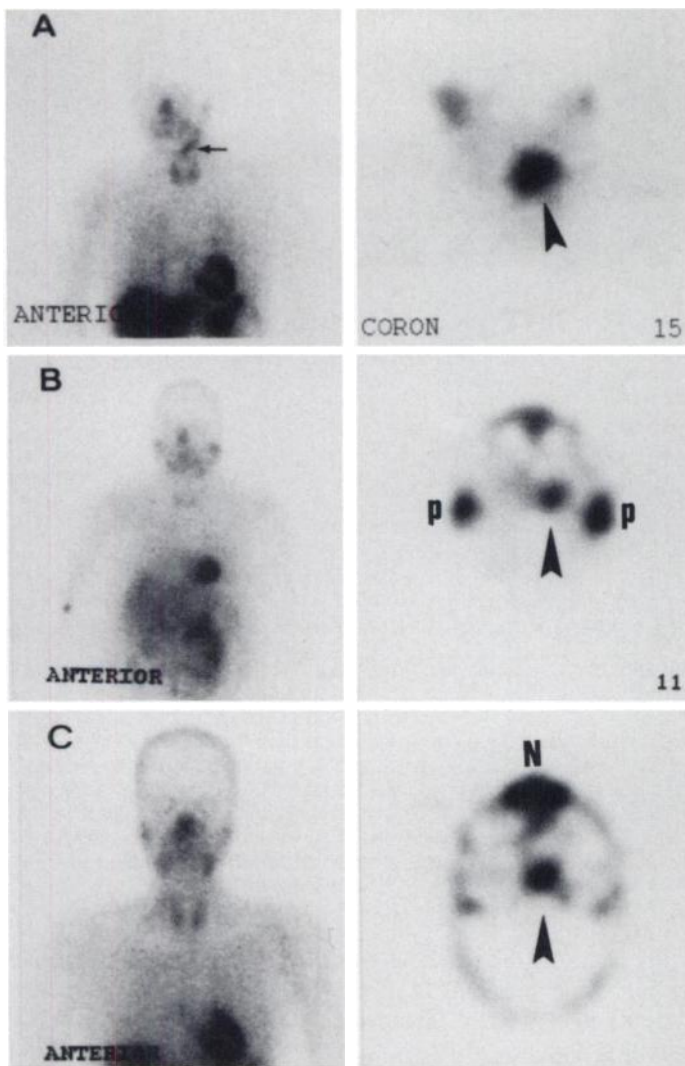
Planar (left) and SPECT (right) ^{201}Tl images. (A) For a hypopharyngeal carcinoma, both planar and coronal SPECT show the tumor (arrows). (B) For malignancies localized in the oropharynx and (C) nasopharynx, only SPECT can indicate the tumor site in, respectively, the left tonsil and left nasopharyngeal (arrows) by differentiating tumor uptake from activity in normal structures (p = parotid glands, n = nose).
